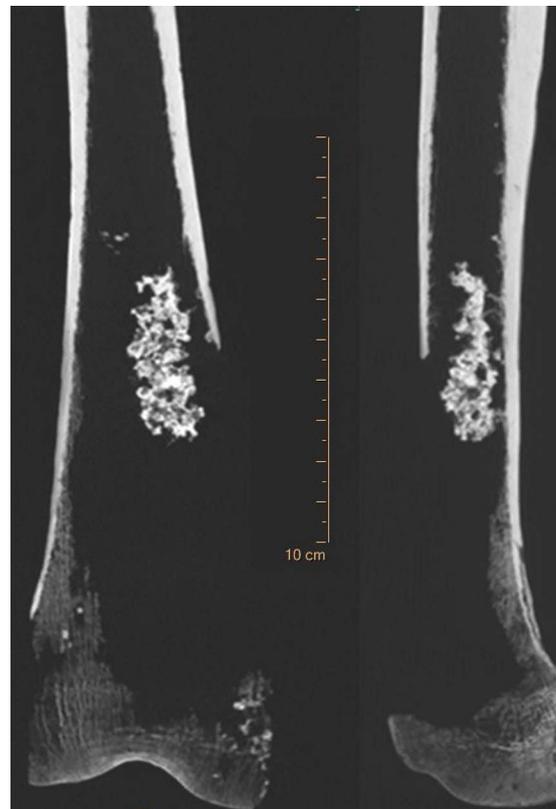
Frontal and lateral view of CT images of distal femur of UF 755 individual. Image B indicates the way in which the calcification is attached to the posterior wall.
